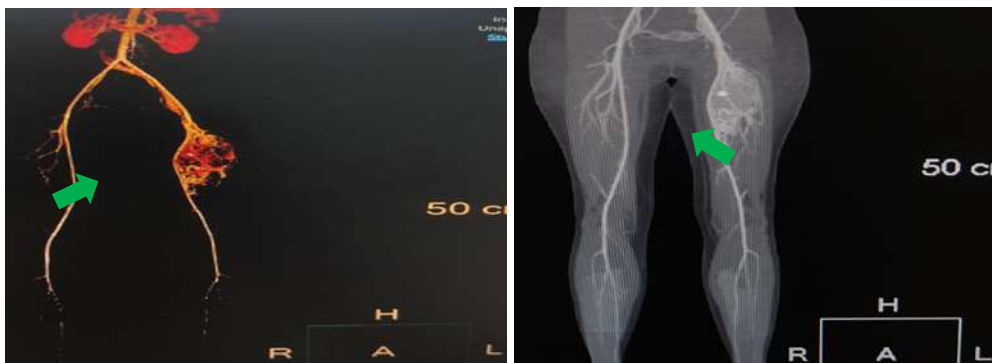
CT Angiography results showed a mass in the proximal region of the left femur with vascular malformation of the branch of the left superficial femoral artery (green arrow).
